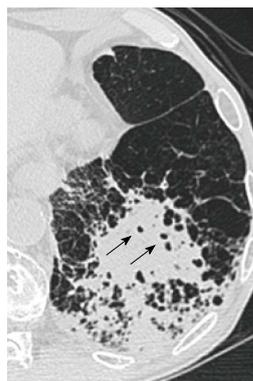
Pneumonia on a background of pulmonary emphysema in a man in his 70s (causative pathogen unknown). Thin-section computed tomography shows patchy consolidations with small air-containing spaces consistent with preexistent low attenuation areas in the left lower lobe.
